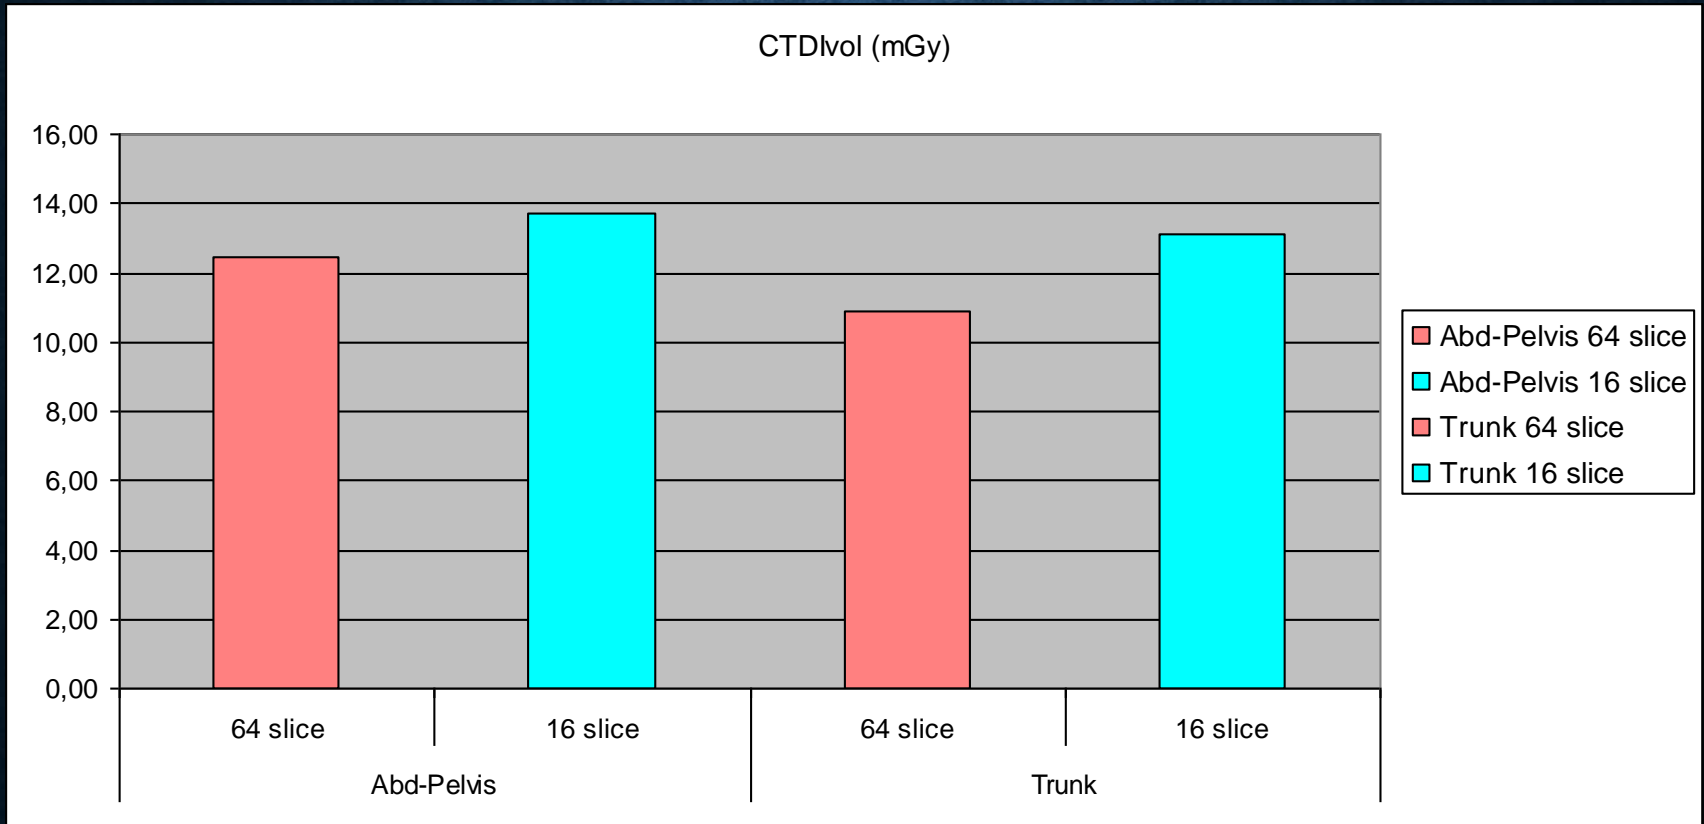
CTDIvol (mGy) for 64 slice and 16 slice CT equipment for AP and CAP procedures
